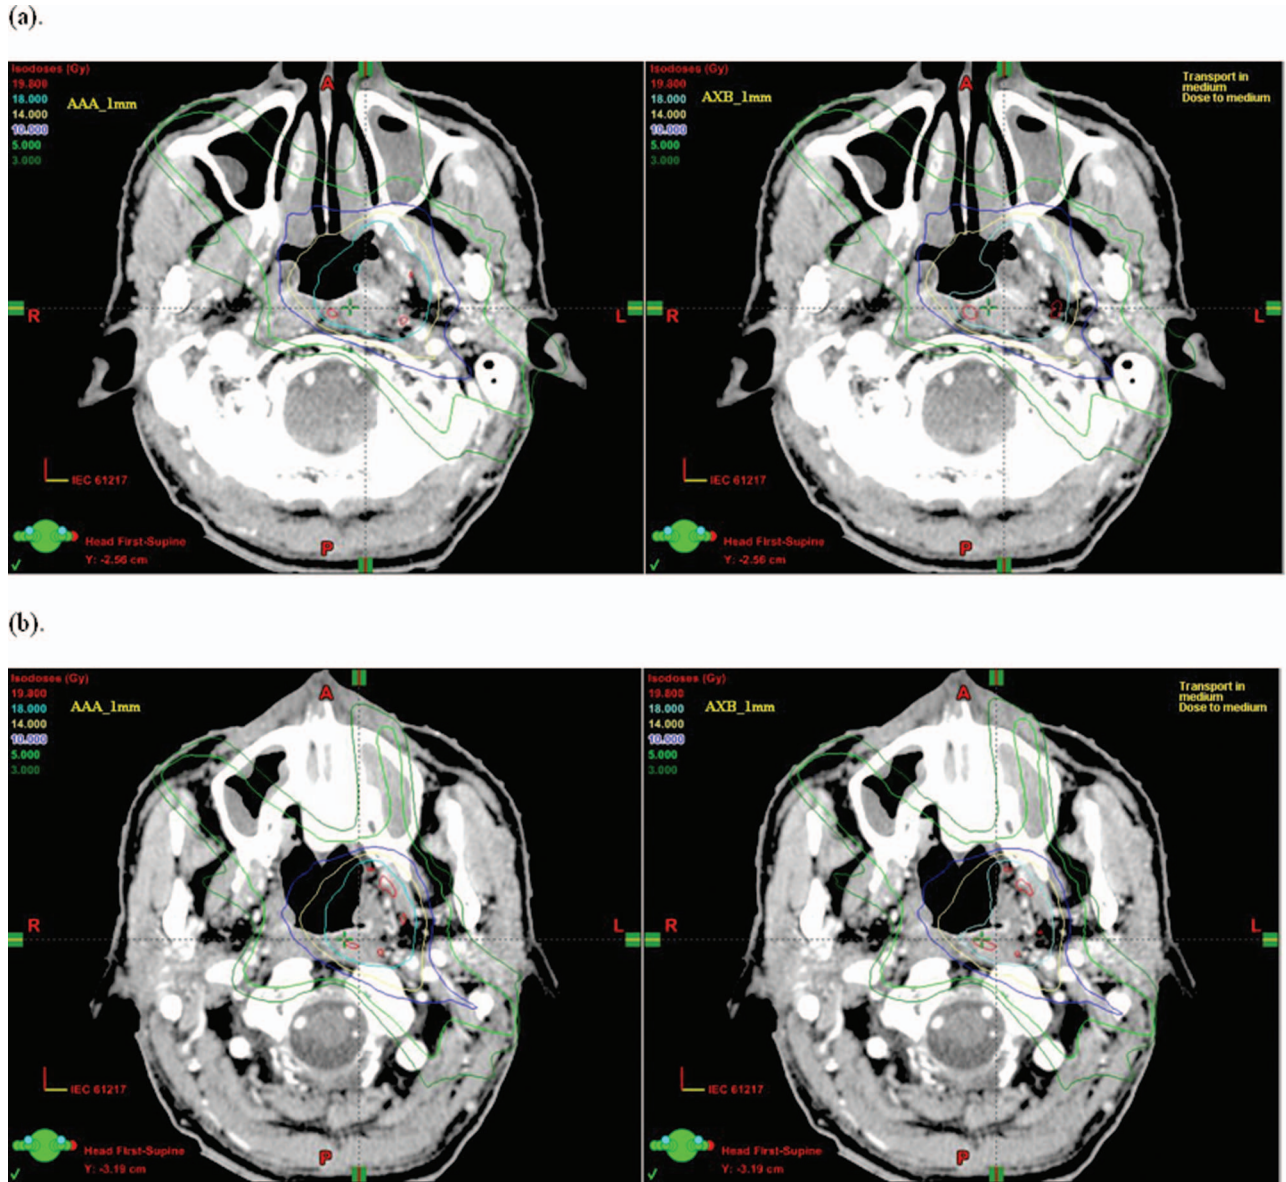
Side by side comparison of isodose distribution on two of the axial CT images, (a) and (b), of a typical patient (case 1 of Fig. 5) AAA_{1.0}mm and AXB_{1.0}mm.
